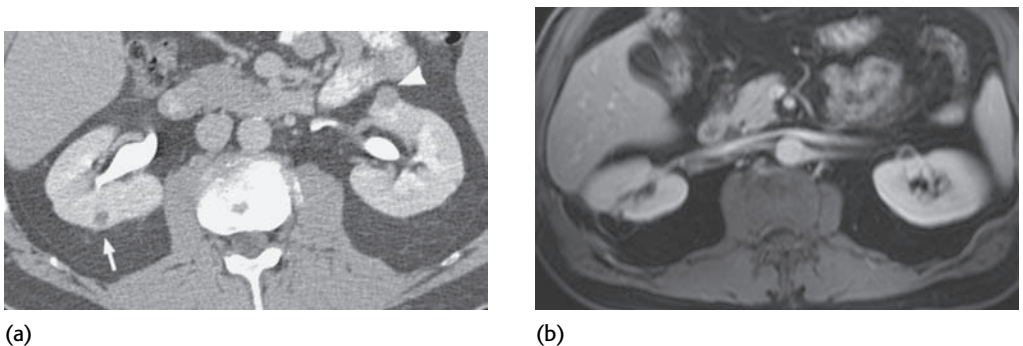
(a) The first study is an axial enhanced CT image showing bilateral small renal tumors (arrow and arrowhead). These are ideally suited for thermal ablation being small and easily accessible. (b) The second study is a post-treatment MRI study.
